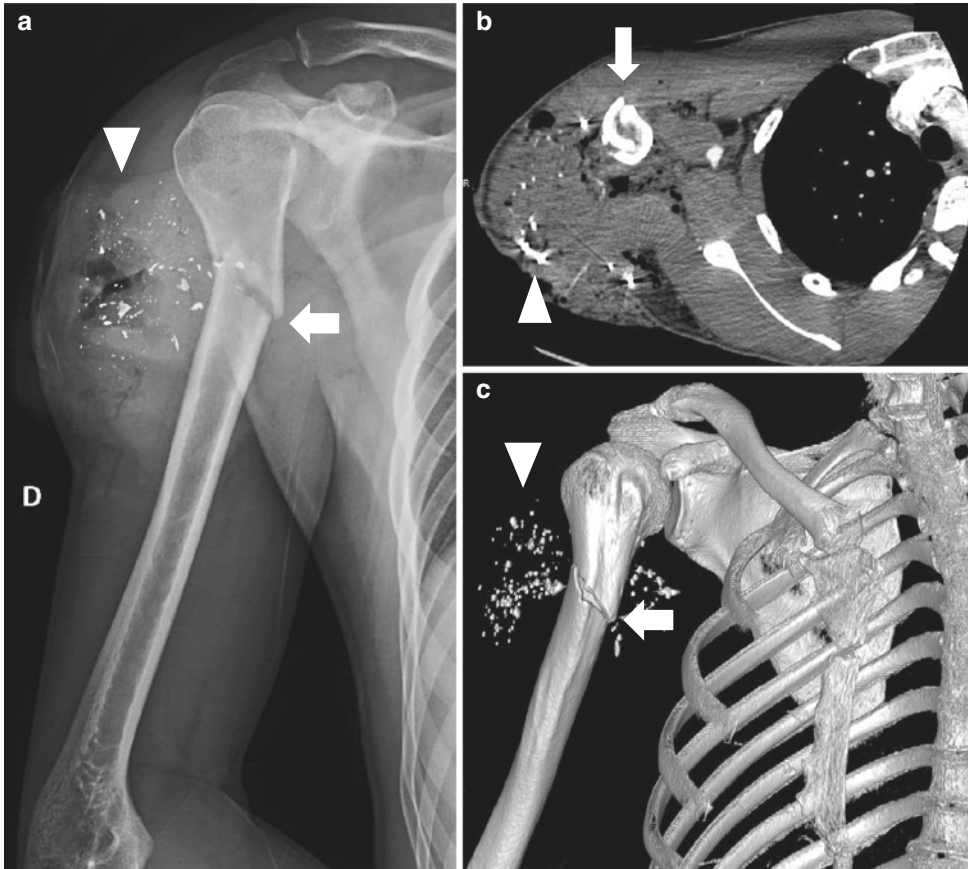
Shoulder X-rays (a) in a 39-year-old patient after a gunshot. Axial CT imaging (a) and VR reconstruction (b) showing humeral shaft fracture (arrows in a–c) and multiple metallic fragments (arrowheads in a–c)
